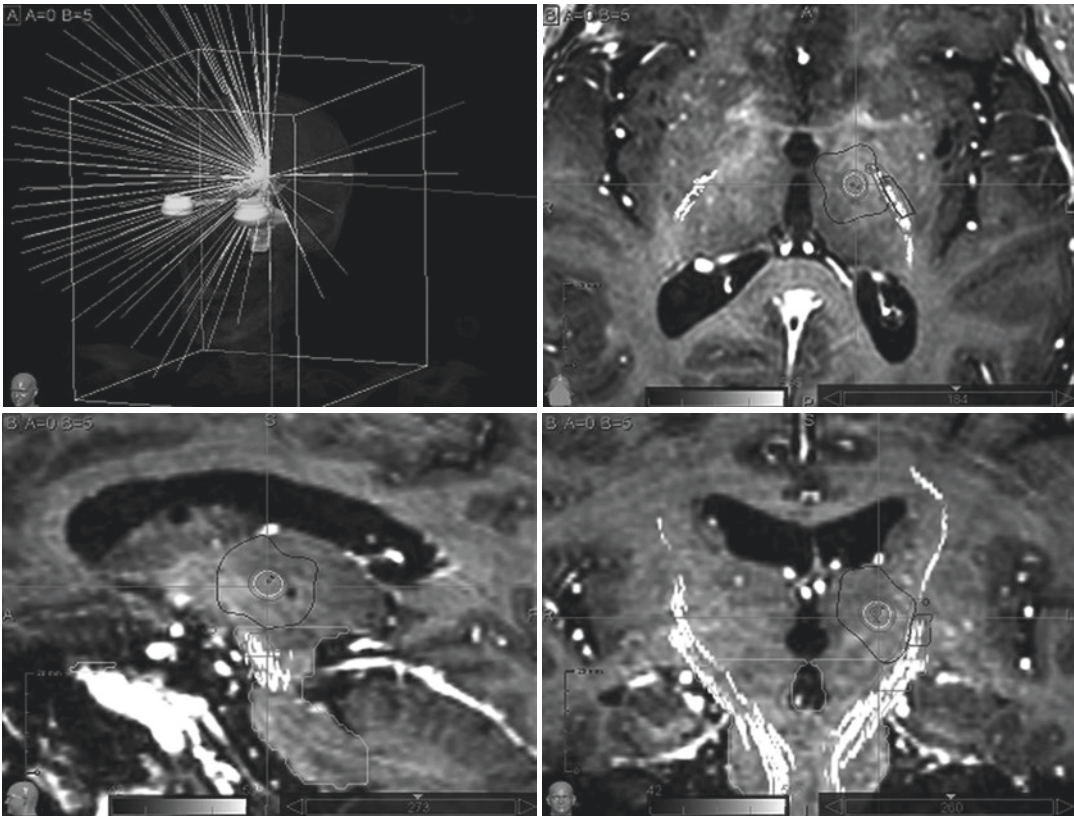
Multimodality imaging, including CT, MRI, and tractography (not mandatory), are utilized to optimize the target definition, the dose distribution and the organs at risk sparing
